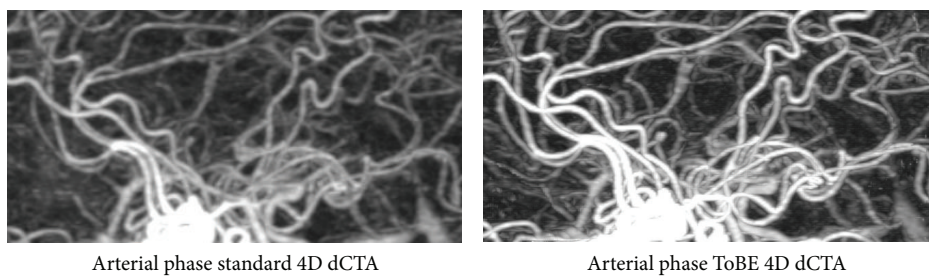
Zoomed in subimages of the arterial phase in one of the evaluated subjects in both the standard 4D dynamic CTA (dCTA) and the proposed ToBE 4D dCTA.
